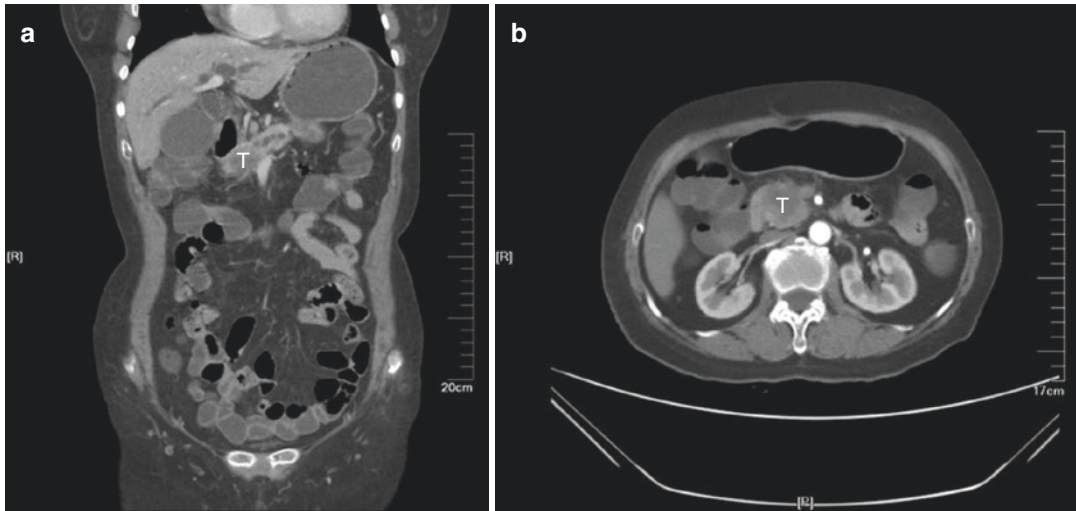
CT image showed a mass in the head of pancreas and a dilation of common bile duct and pancreatic duct. (a) A mass in the pancreatic head, the bile duct and pancreatic duct were dilated. (b) The mass in the pancreatic head. T = tumor
